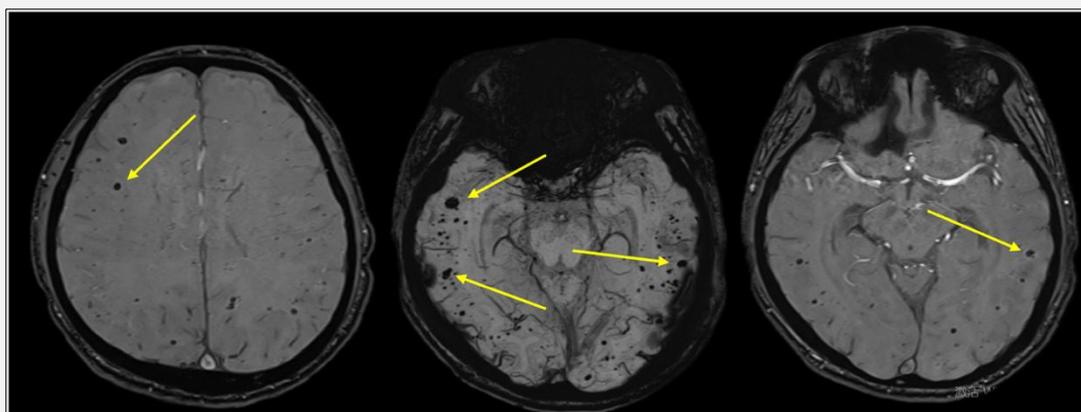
MRI susceptibility-weighted imaging (SWI) sequence demonstrates diffuse punctate hypointense signals.
